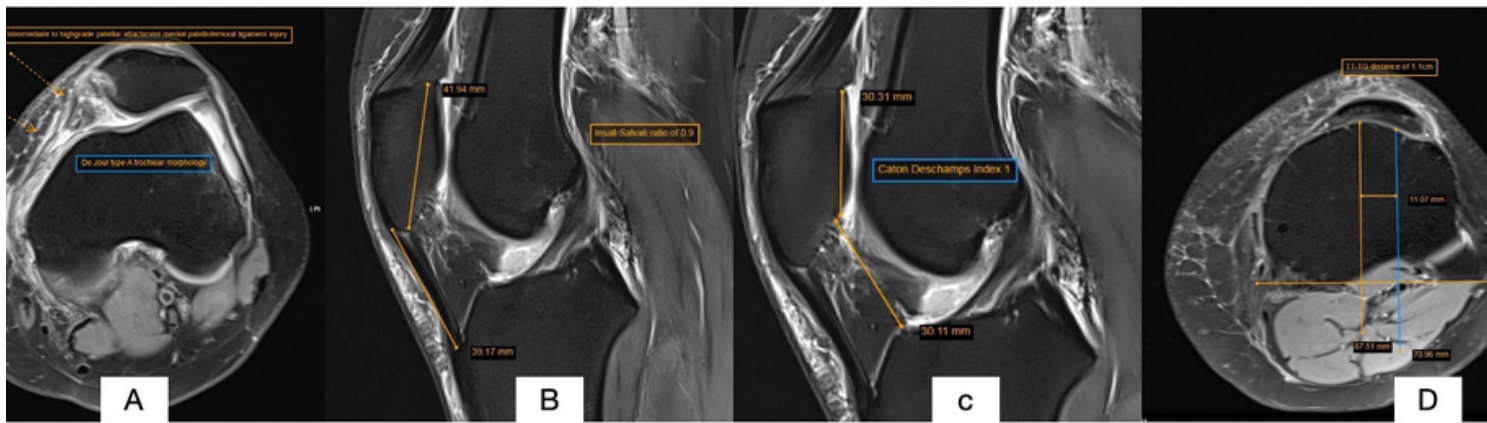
MRI scan. A: Axial cuts showing high grade MPFL tear at Patella attachment with Dejour type A trochlear dysplasia, B: Sagittal section showing normal Insall Salvati ratio 0.9, C: Caton Deschamps index 1 & D: TT-TG distance 11mm
